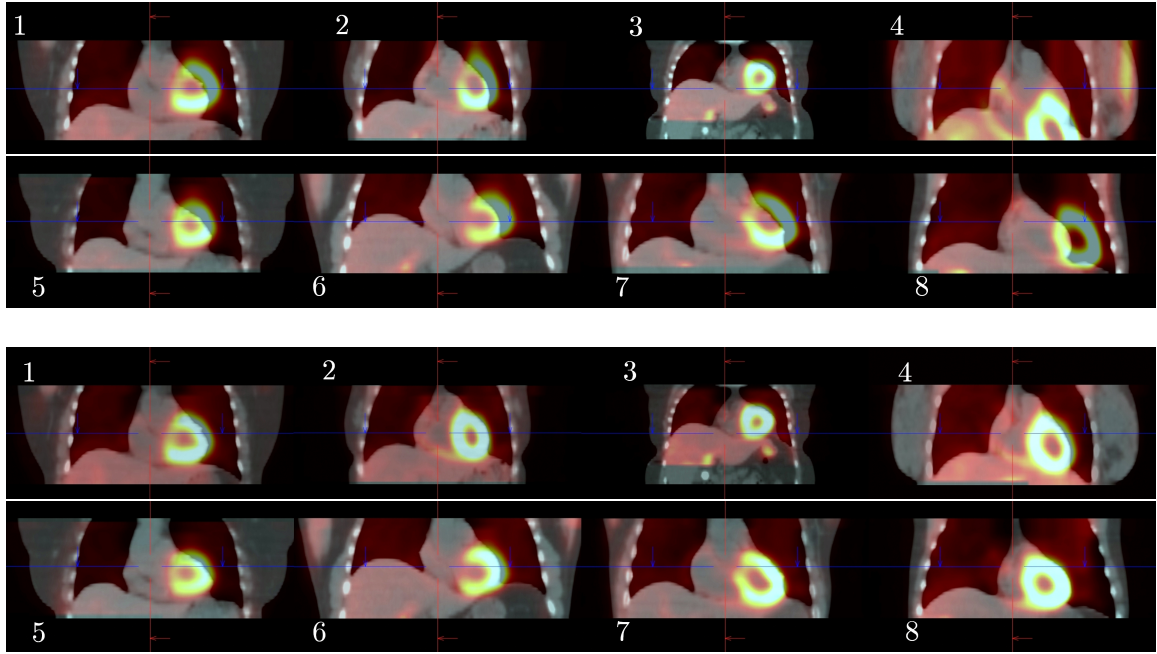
Top: Fused anterior views of eight cardiac SPECT/CT data sets after non-rigid registration using mutual information (MI). Most of the registrations failed due to convergence to a local optimum of MI. Bottom: The fused views of the same subjects as on top after non-rigid registration using a statistical intensity prior to support MI. The data sets are now successfully registered through the use of prior knowledge about correct alignment.
